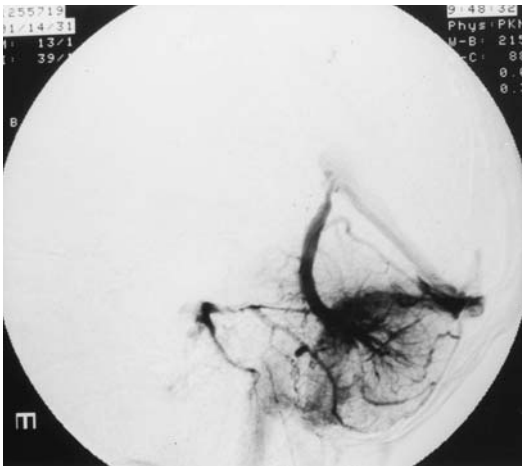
Case 5: A 69-year-old woman with new-onset headaches received an MRI, revealing a cerebellar vascular malformation. Lateral view of a venous phase left vertebral artery cerebral angiogram revealed a centripetal venous cluster in the right cerebellar hemisphere, which drained into a dilated pre-central cerebellar vein that subsequently emptied into the straight sinus. These angiographic features are typical of a DVA. The patient's headaches were medically managed.
